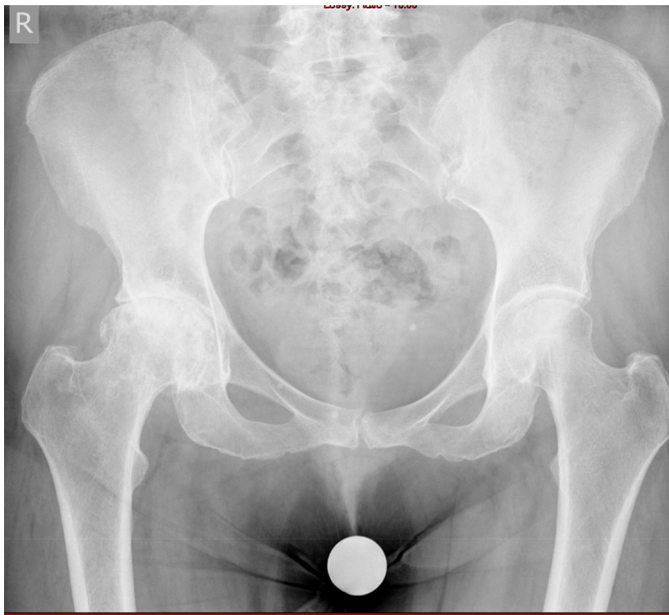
Pre-operative radiograph showing right hip osteoarthritic changes.
